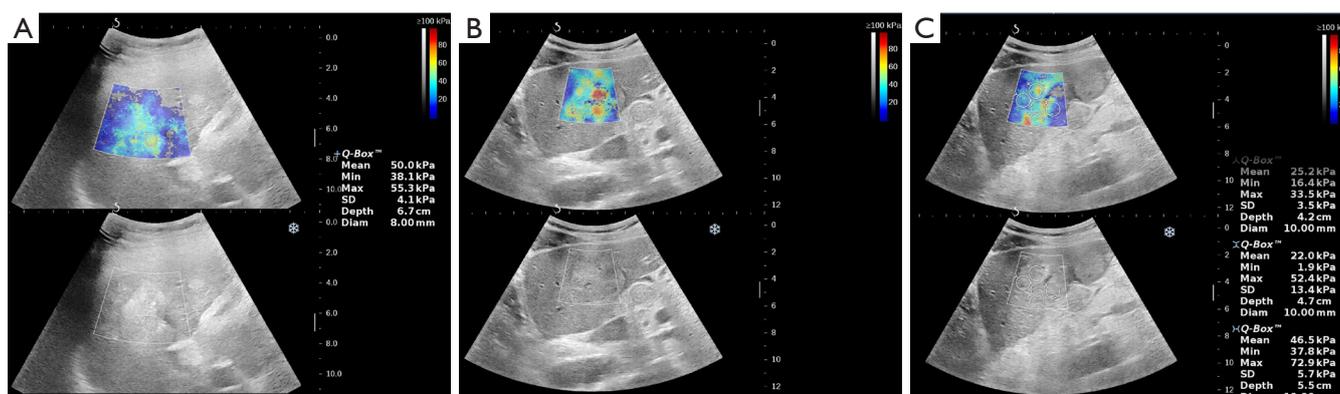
TS measurement using ultrasound elastography US-E. (A) The US-E measurement result of a local tumor before TACE demonstrated a TS value of 50 kPa. (B) The US-E measurement result of a local tumor before TACE demonstrated a TS value of 72 kPa. (C) The US-E measurement result of a local tumor before TACE demonstrated a TS value of 25.2 kPa. TS, tumor stiffness; TACE, transarterial chemoembolization; US-E, ultrasound elasticity.
